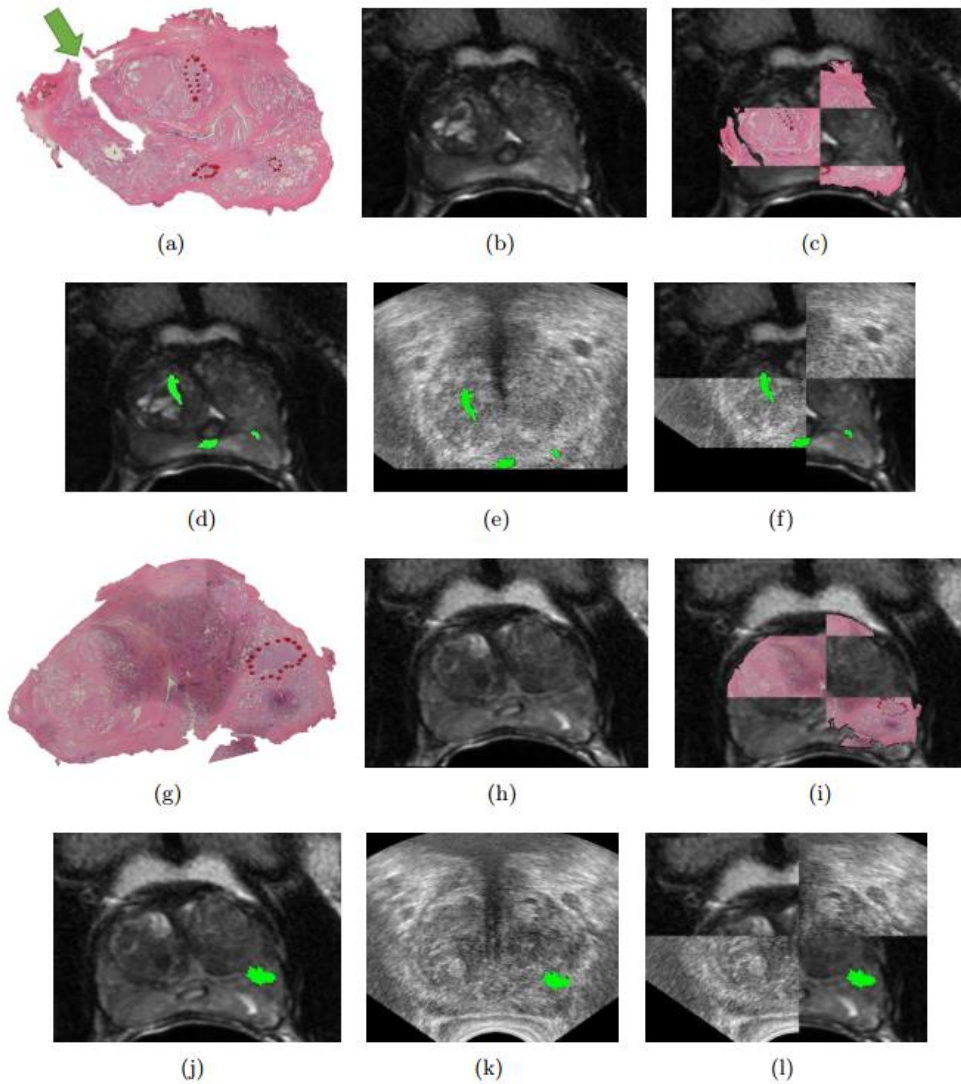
Registration of MRI, TRUS and WMH: Two 2D planar images of (a),(g) WMH and (b),(h) corresponding MRI. (c),(i) WMH and MRI checkerboard overlays showing alignment between the two modalities. (d),(j) MRI with cancer annotation obtained from WMH (green). (e),(k) TRUS with cancer annotation obtained from WMH (green). (f),(l) Fused MRI-TRUS images shown as checkerboards with cancer annotation obtained from WMH (green).
